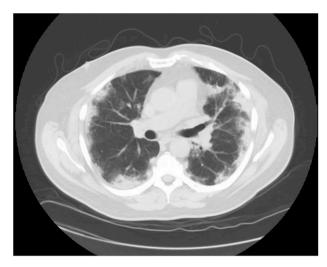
HRCT scan chest showing extensive peripheral opacities.
